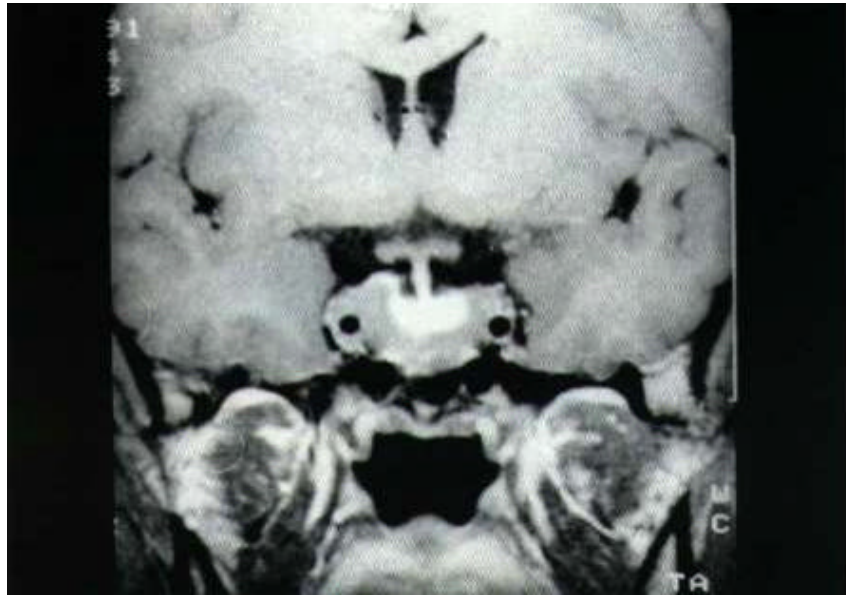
MRI image (coronal view) of case 2.
